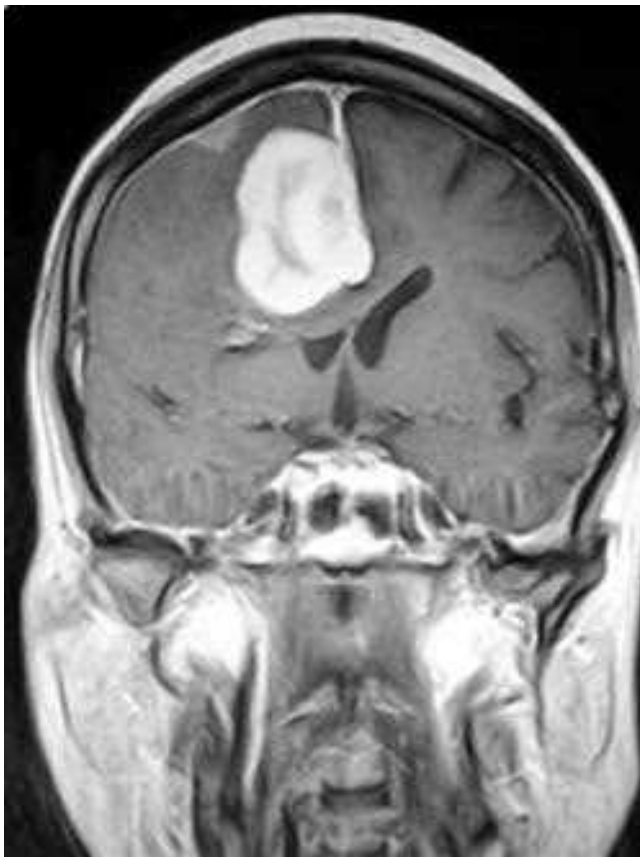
Postcontrast T1-weighted coronal magnetic resonance imaging demonstrating a brightly enhancing lesion arising from the falx cerebri with moderate edema and mass effect on the right lateral ventricle. This is a falcine meningioma. Note also the small separate meningioma arising from the dura over the cerebral convexity.
